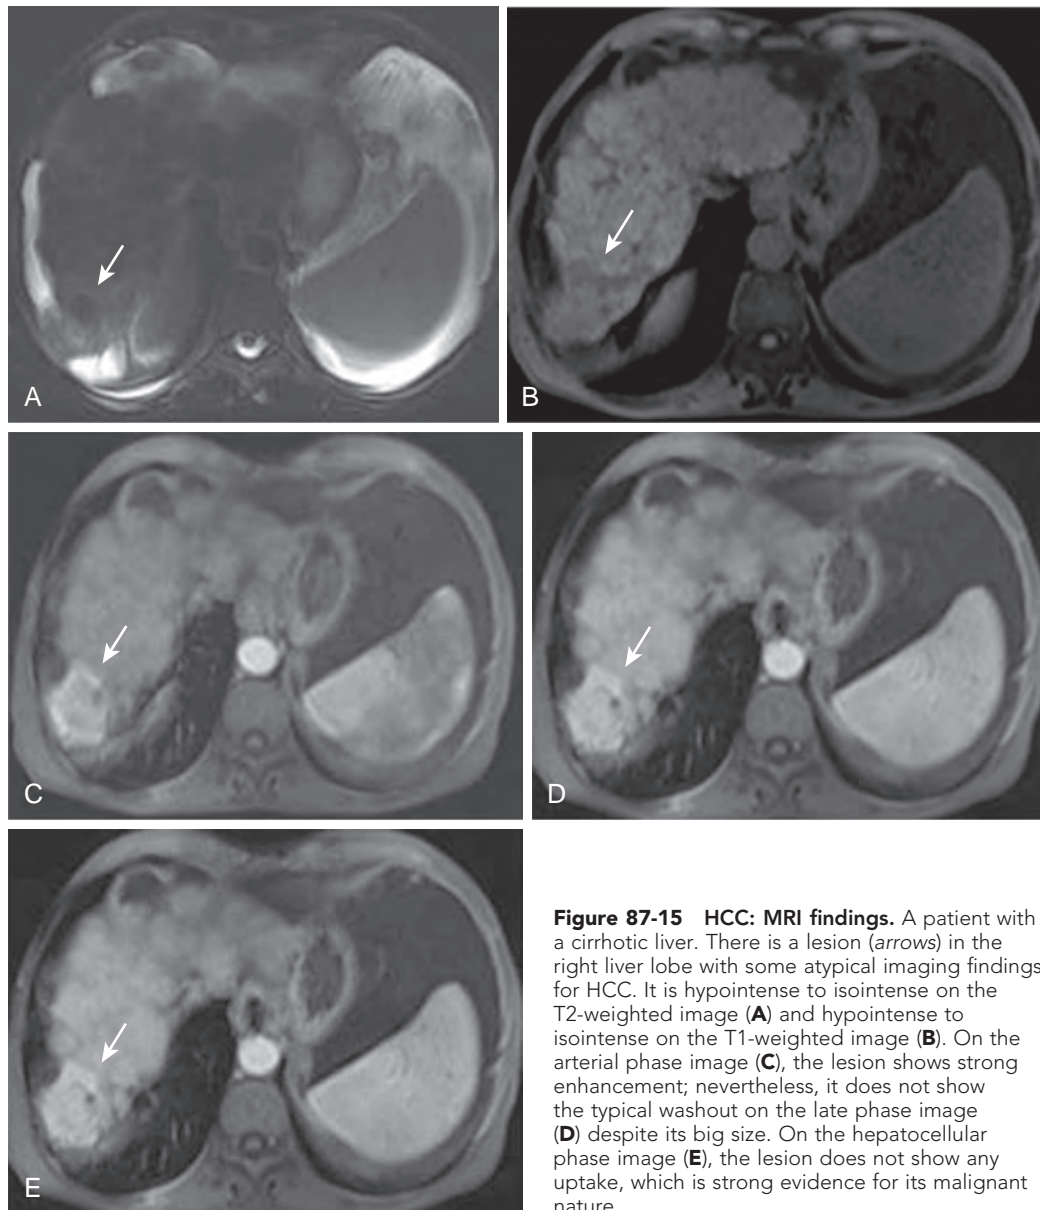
HCC: MRI findings. A patient with a cirrhotic liver. There is a lesion (arrows) in the right liver lobe with some atypical imaging findings for HCC. It is hypointense to isointense on the T2-weighted image (A) and hypointense to isointense on the T1-weighted image (B). On the arterial phase image (C), the lesion shows strong enhancement; nevertheless, it does not show the typical washout on the late phase image (D) despite its big size. On the hepatocellular phase image (E), the lesion does not show any uptake, which is strong evidence for its malignant nature.
